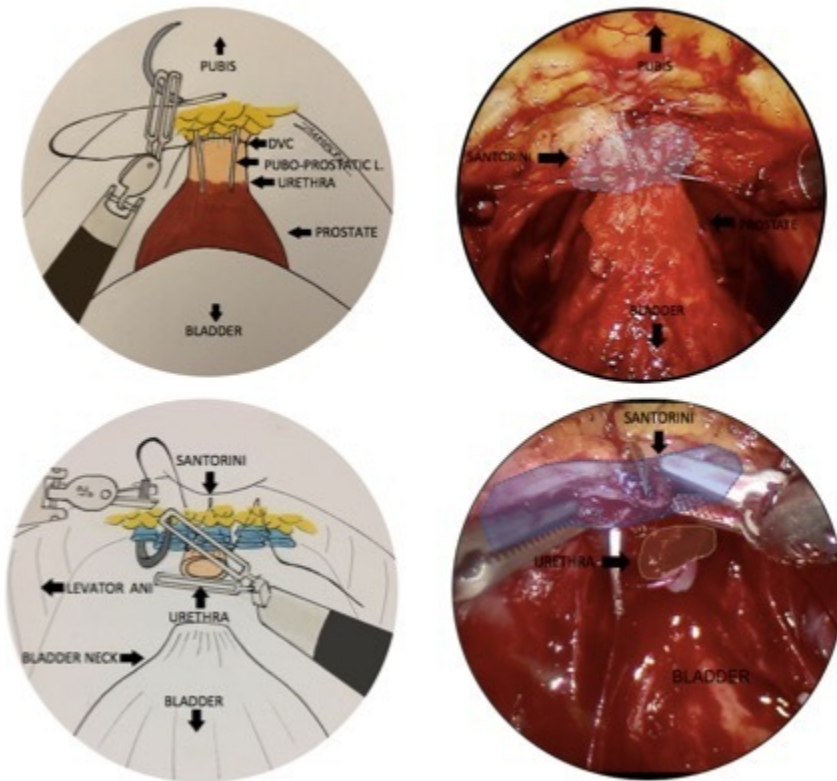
Standard ligation of DVC:* after opening the endopelvic fascia and lateral dissection of prostate up to the apex, a eight-figure 1-0 CT-1 stitch was given, without including pubo-prostatic ligaments; transection of the DVC was postponed at the end of prostatectomy before the section of the urethra.
